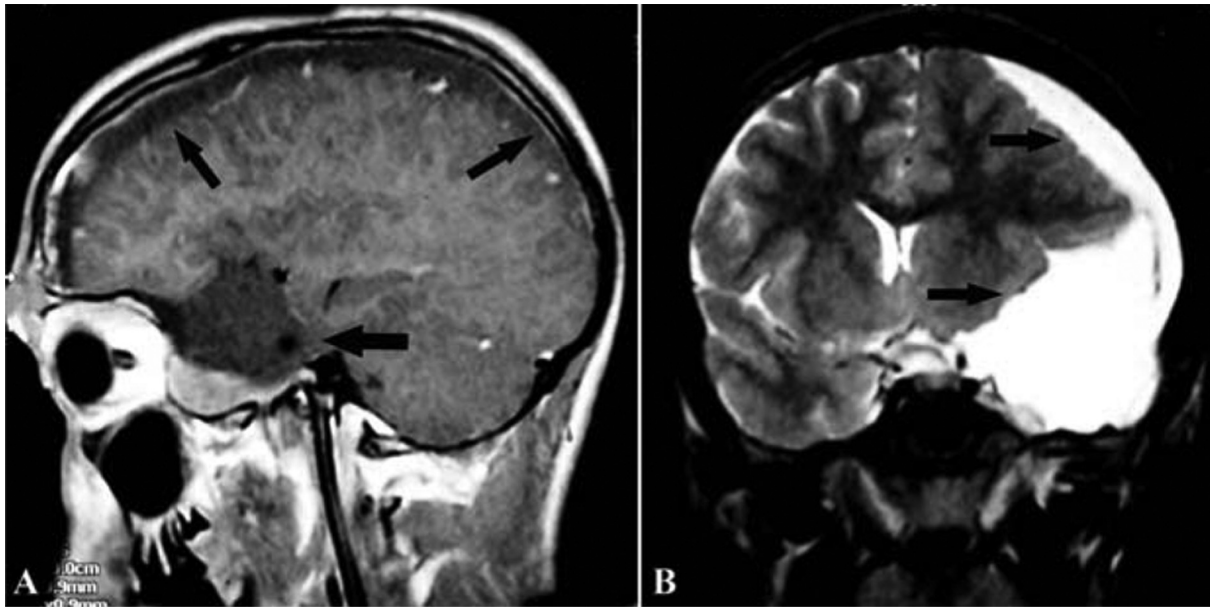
Sagittal T1 post contrast Magnetic Resonance Imaging (MRI) scan (a) and T2 sequence MRI scan clearly demonstrating arachnoid cyst, subdural haematoma and intracystic hemorrhage (arrows)
